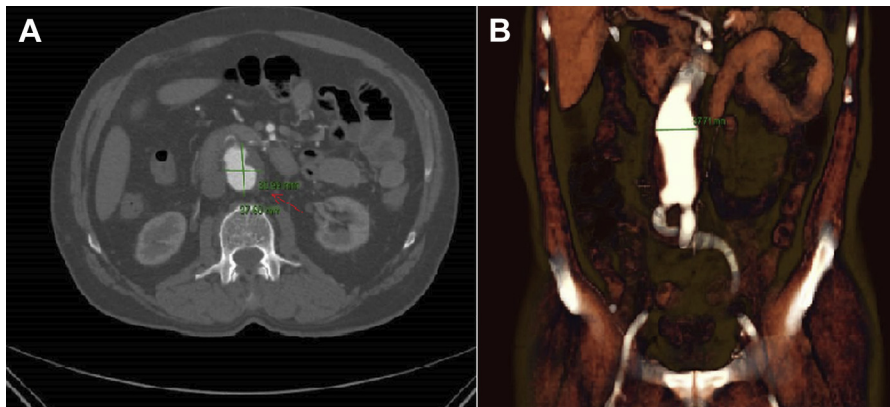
Computed tomography (CT) of the abdomen during arterial phase showing an infrarenal abdominal aorta aneurysm of 31 × 38 mm; the *arrow* shows wall thickening and inflammatory fat stranding changes localized at the aneurysm wall in a patient who had high *Brucella* serology titer. A, Axial view. B, Coronal three-dimensional view.
